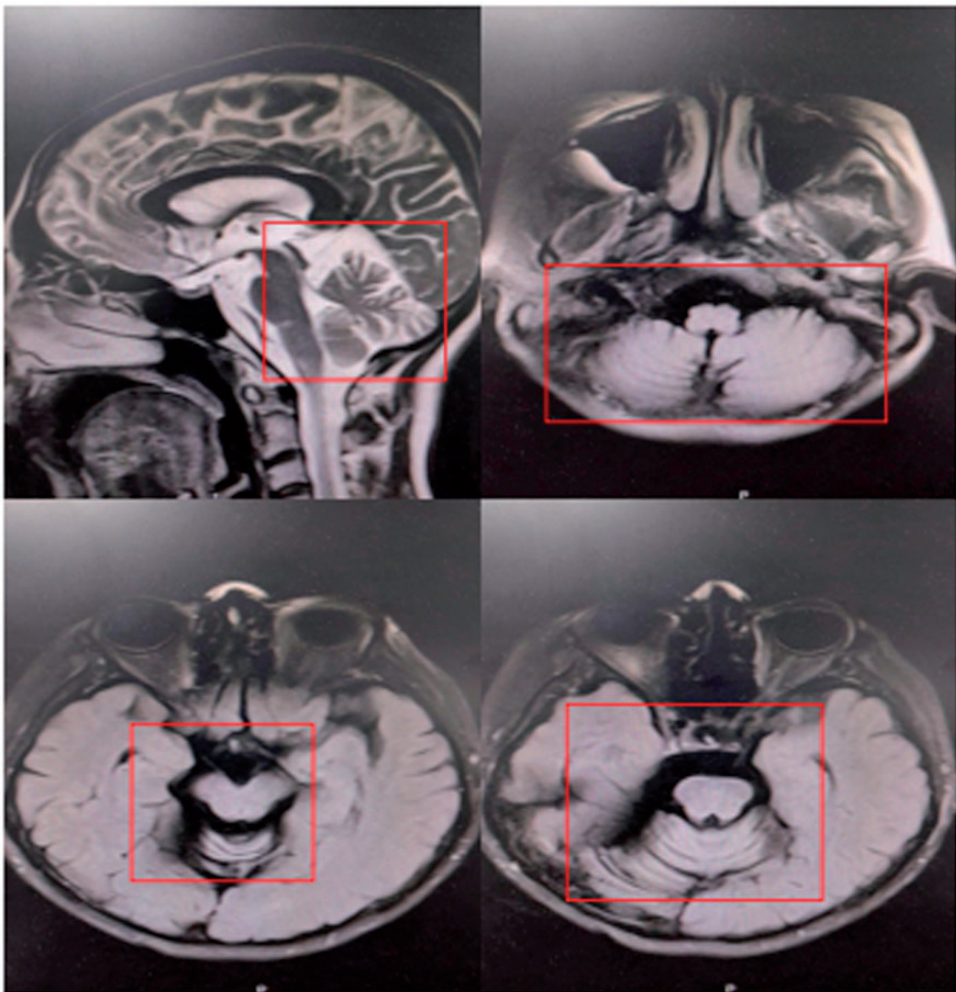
Magnetic resonance images of a 60-year old female patient who presented with syncope for 1 year combined with dizziness for 1 day. The patient had been diagnosed twice with transient ischaemic attack during the previous 6 months. The images show a widening of the cerebellar sulcus and mild brain atrophy. All four figures show cerebral atrophy (box and arrows).
